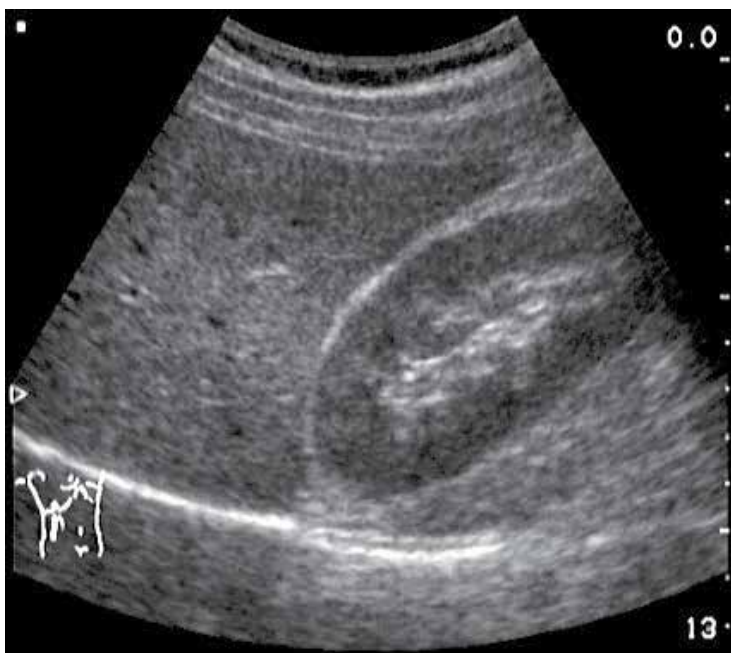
Normal ultrasound liver pattern. Echogenicity and echodensity of the liver and the kidney are similar.
